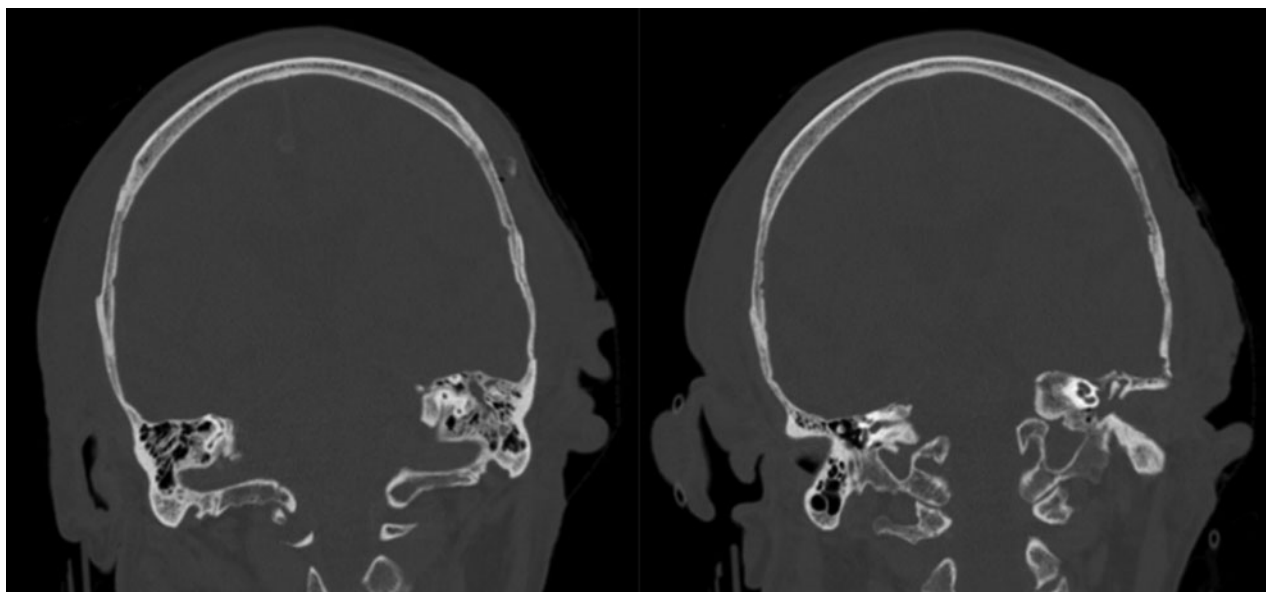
Example of middle-ear and mastoid opacification scoring. Non-contrast coronal computed tomography images of the head of a patient with a total middle-ear and mastoid opacification score of 3: partial opacification of left mastoid (1 point) and total opacification of left middle ear (2 points).
